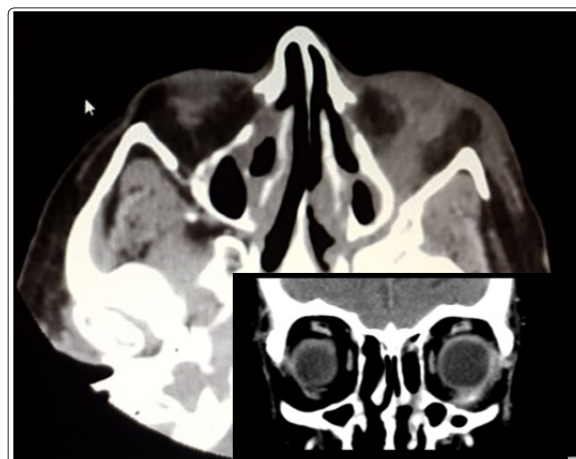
CT-scan, excluded the presence of the suspected infraorbital abscess but highlighted an enlarged inferior oblique muscle, October 2017
